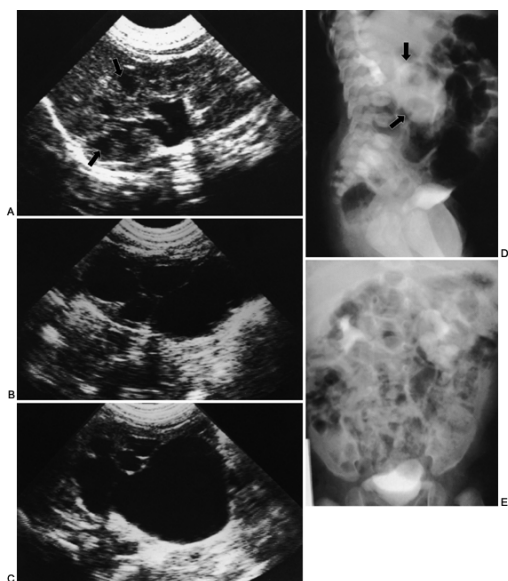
A: Normal neonatal renal ultrasound. Note prominent intrarenal pelvis and corticomedullary junctions (*arrows*). B, C: Renal ultrasounds in newborn with left ureteropelvic junction obstruction. Note large renal pelvis communicating with clubbed calyces. Cortex is quite thin. D: Intravenous pyelogram (IVP) performed at 1 week of age. Film was taken 1 hour and 45 minutes after injection. Note large left renal pelvis (*arrows*) of the left kidney. Patient underwent pyeloplasty in the neonatal period. E: IVP 2.5 months postpyeloplasty, a 15-minute film. Visualization of the left kidney was prompt. Note persistently clubbed calyces.
